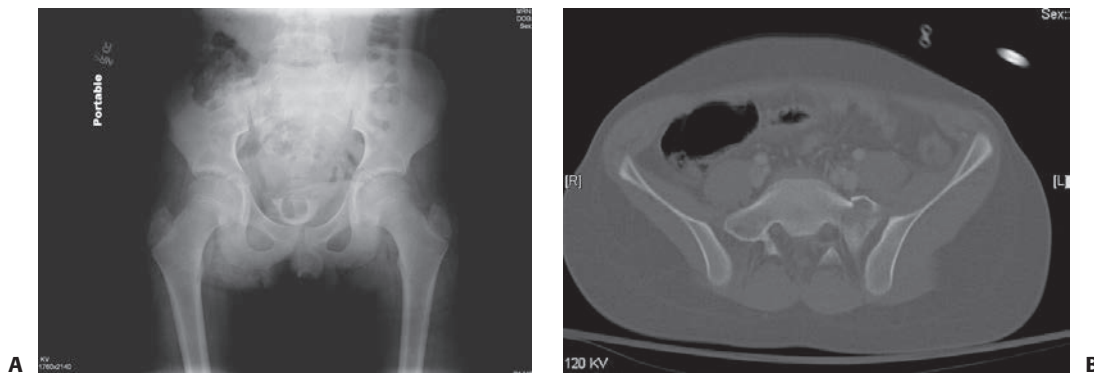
A: An example of an anterior–posterior pelvic radiograph where the sacral fracture is not well visualized. B: CT scan of the patient showing the sacral fracture.
